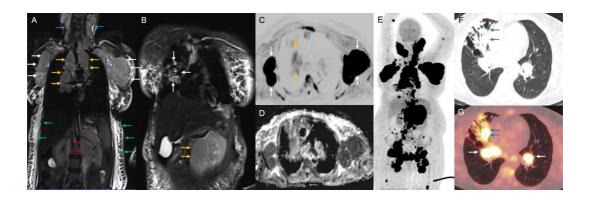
Stage IV on both WB-MRI and PET-CT. A. Coronal STIR image showing multiple large nodal masses in the bilateral cervical (blue arrows), mediastinal (yellow arrows) axillary (white arrows) para-aortic (red arrows) stations. Diffuse subcutaneous oedema (green arrows) is seen as likely due to lymphatic and venous obstruction due to disease involvement. B. Coronal STIR image showing bronchiectasis and lung nodules in the right lung (white arrows). The image also shows a large mesenteric nodal mass. C & D. Axial DWI image and ADC maps showing diffusion restricting axillary masses (white arrow), sternal & rib lesions (blue arrows). The right lung changes (yellow arrow) are not as prominent as seen in STIR images. E. Coronal MIP PET-CT image showing extensive FDG avid lesions involving the bilateral cervical, axillary, mediastinal, hilar, right lung, mesenteric, para-aortic, iliac and inguinal stations. F. Axial lung window image showing patchy areas of consolidation with cavitation in the right middle lobe (blue arrows) with associated bronchiectasis – likely due to infective aetiology. G. Axial PET-CT showing FDG uptake in the infective lesions (blue arrows).
